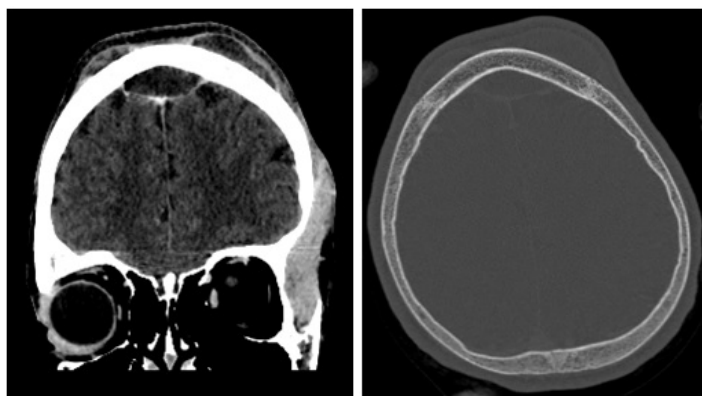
(A) Coronally-reformatted, soft tissue algorithm image from a contrast-enhanced head CT demonstrates bilateral frontal subperiosteal collections and an epidural collection with downward displacement of the superior sagittal sinus. (B) Axial, bone algorithm image shows a mildly expanded diploic space but otherwise normal appearance of the frontal calvarium.
